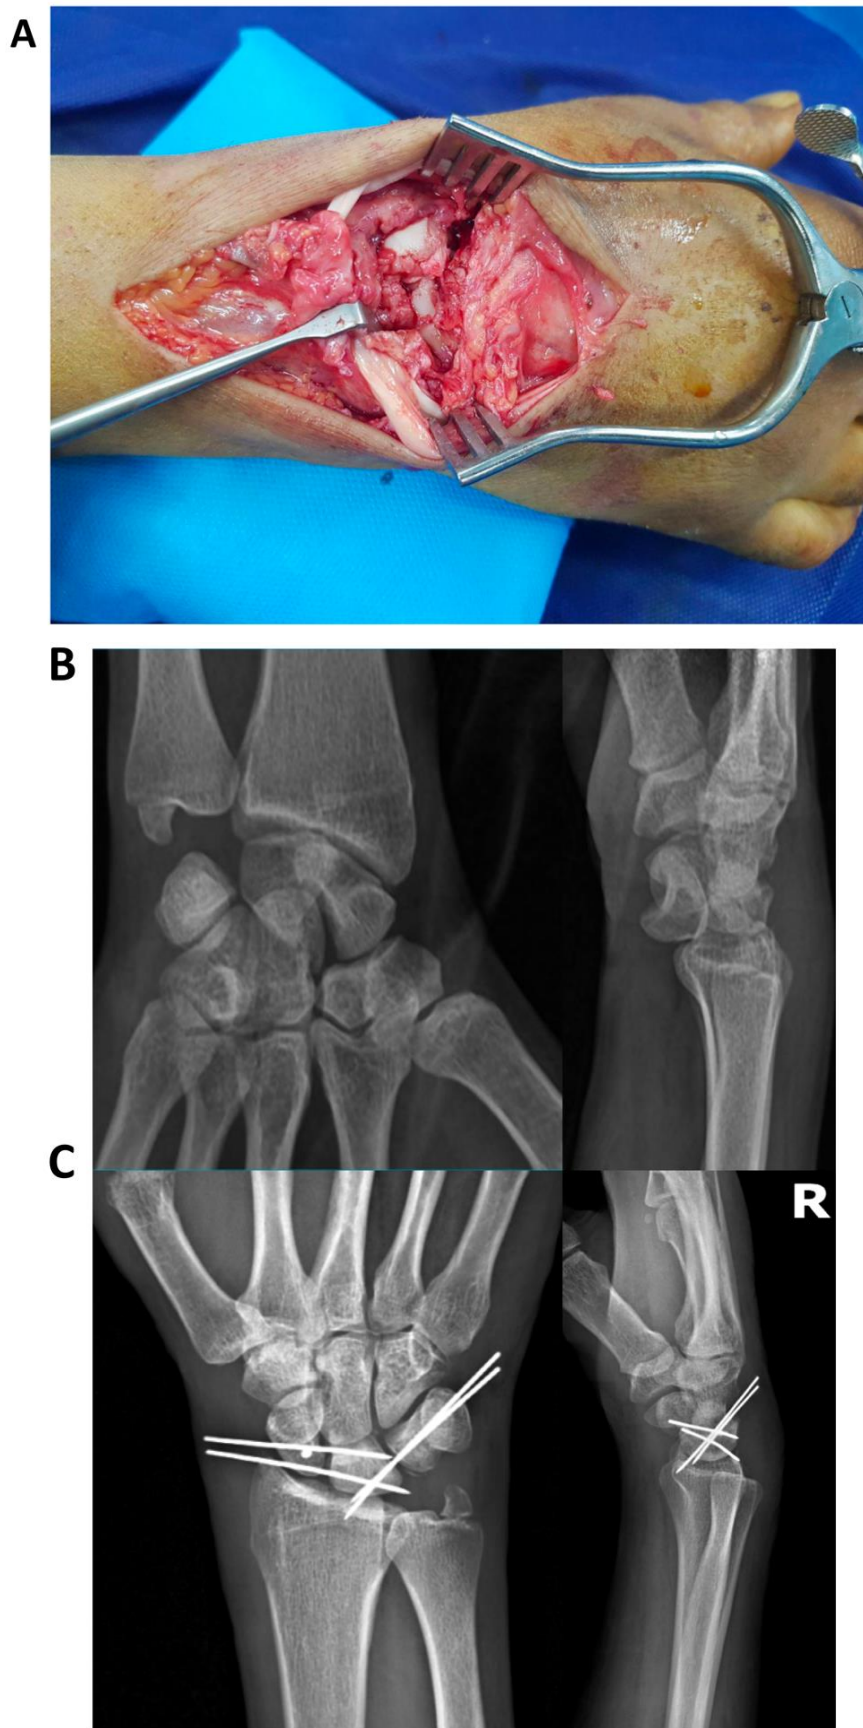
(A) Dorsal approach (B) preop and (C) postop radiograph in a 38 male with Perilunate dislocation (PLD)
